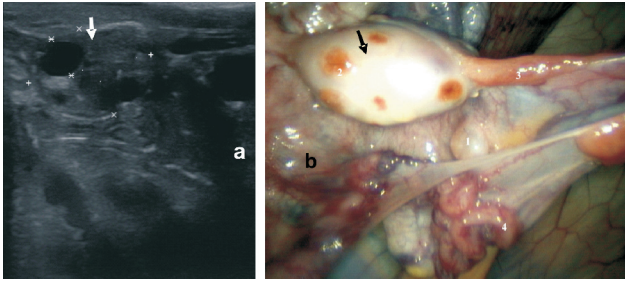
Inactive ovary (arrow). (a) Ultrasound image (b) Laparoscopic image.
